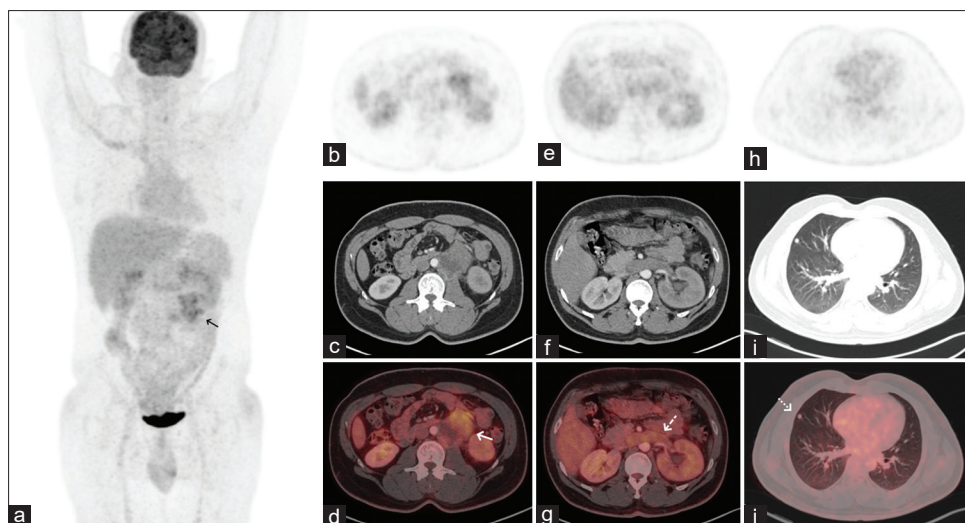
Whole-body fluorodeoxyglucose positron emission tomography MIP image (a) reveal increased tracer uptake in the left lumbar region (black arrow). Transaxial positron emission tomography, computed tomography, and fused positron emission tomography-computed tomography images localize the increased tracer uptake to fluorodeoxyglucose-avid solid-cystic soft-tissue mass (white solid arrow; b-d) in left-sided retroperitoneum invading left renal vein (e-g: white dashed arrow; g) along with random right lung nodule (h-j):white dotted arrow; j).
